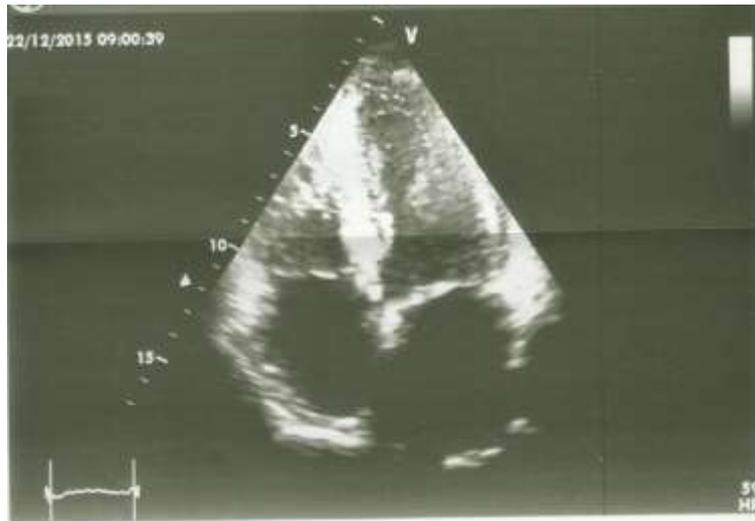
Echocardiographic image of apical four chambers view showing normal wall motion.
